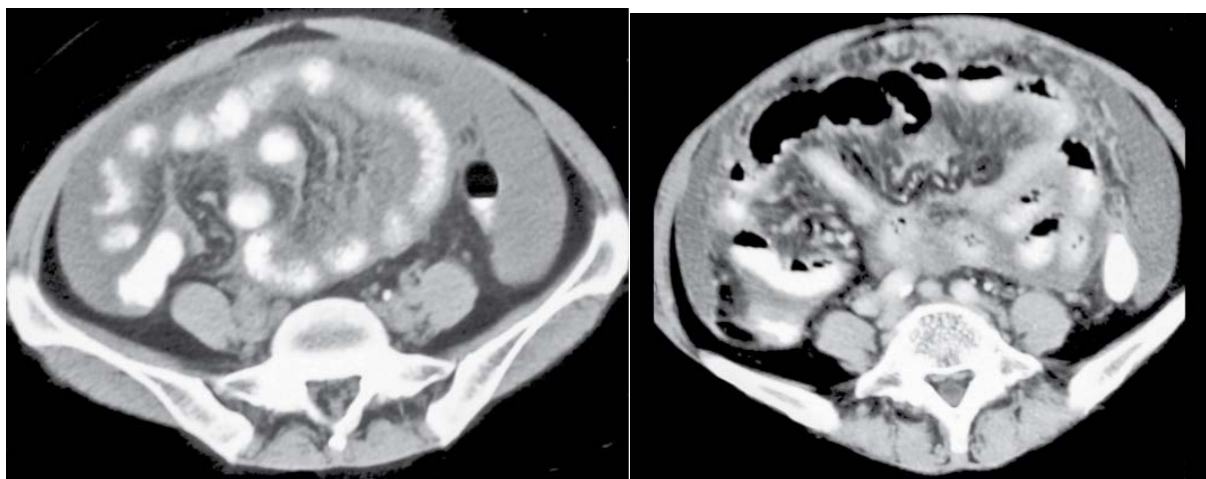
CT scan of abdomen showing features of abdominal tuberculosis.
